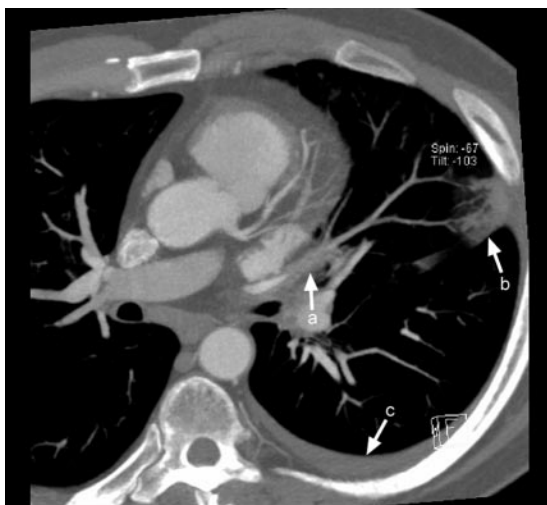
This chest computed tomogram shows (a) new thrombosis of the lingular branch of the pulmonary vein, (b) pulmonary infarction, and (c) small pleural effusion.
